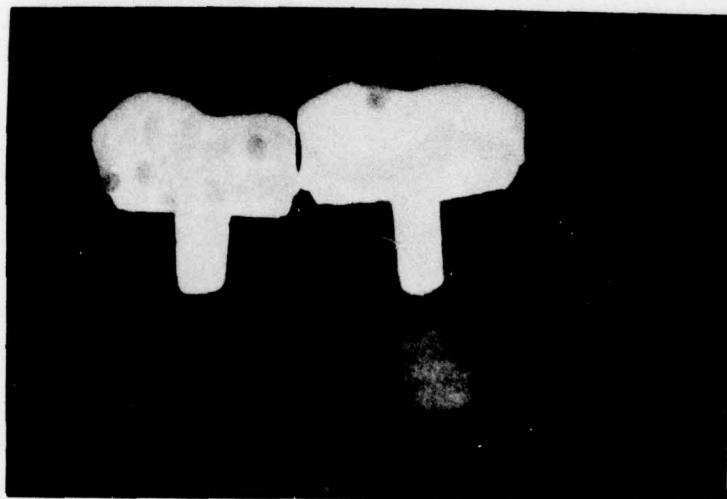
RADIOGRAPH OF IMPLANTS IN FUNCTION FOR
